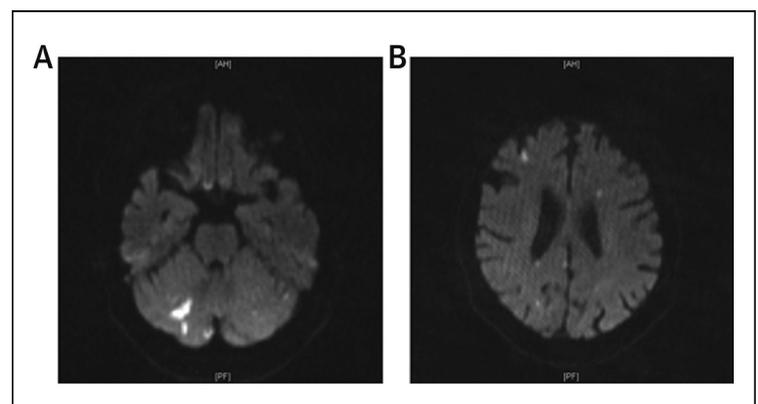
DW-MRI Findings After TAVR
